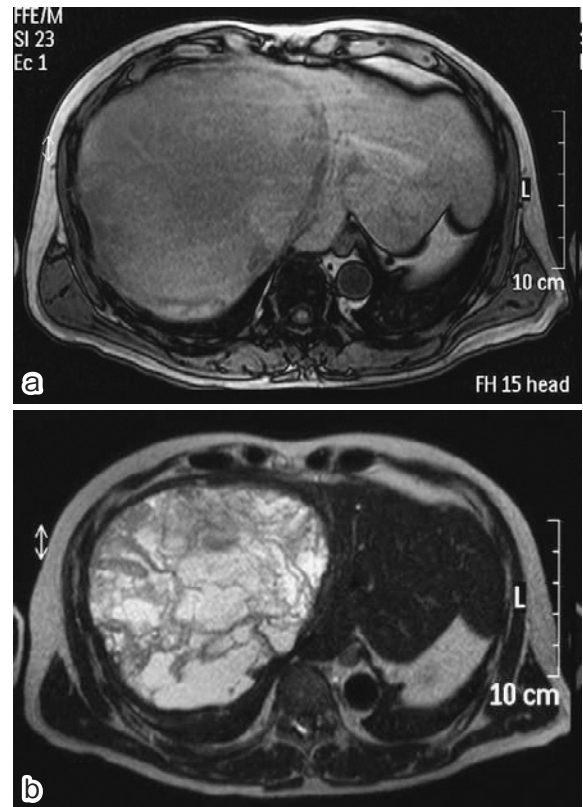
MRI revealed a heterogeneous hypointense lesion 20 cm in diameter with linear hyperintense areas on T1-weighted sequences (a) and mosaic heterogeneous hyperintensity on T2-weighted sequences (b).
